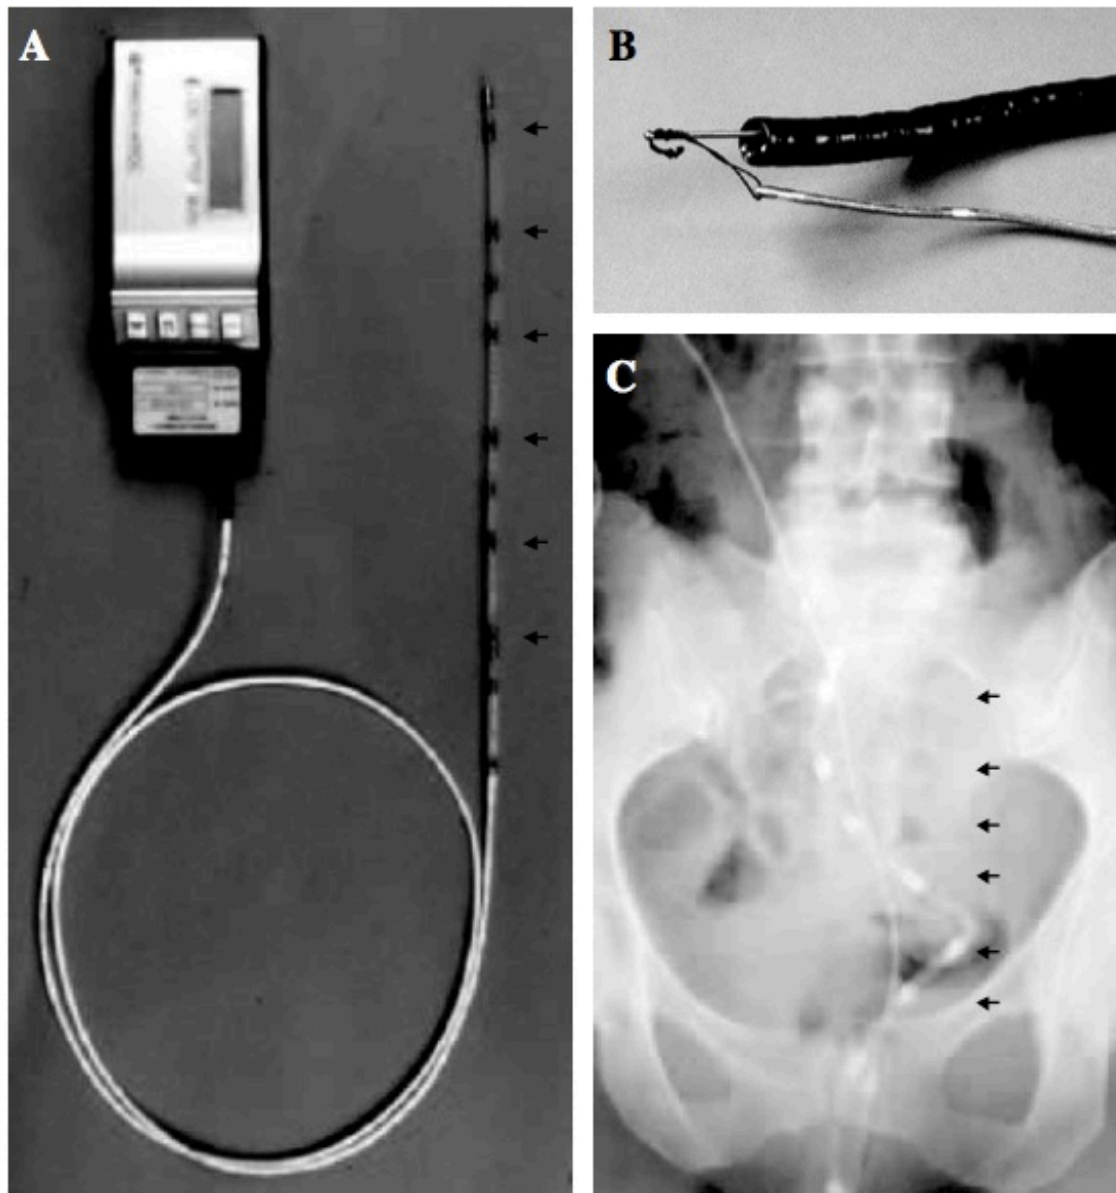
Solid-state manometric recording equipment. (A) six-channel solid-state catheter attached to a portable recorder with 6 microtransducer pressure sensors are arrowed; (B) a strong silk thread attached to the tip of the catheter and grasped by biopsy forceps to facilitate colonoscopic-assisted intubation; (C) plain radiograph of the catheter *in situ* in the left colon with radio-opaque pressure sensors (arrowed). (Images adapted from Scott (Scott, 2003) with permission).
